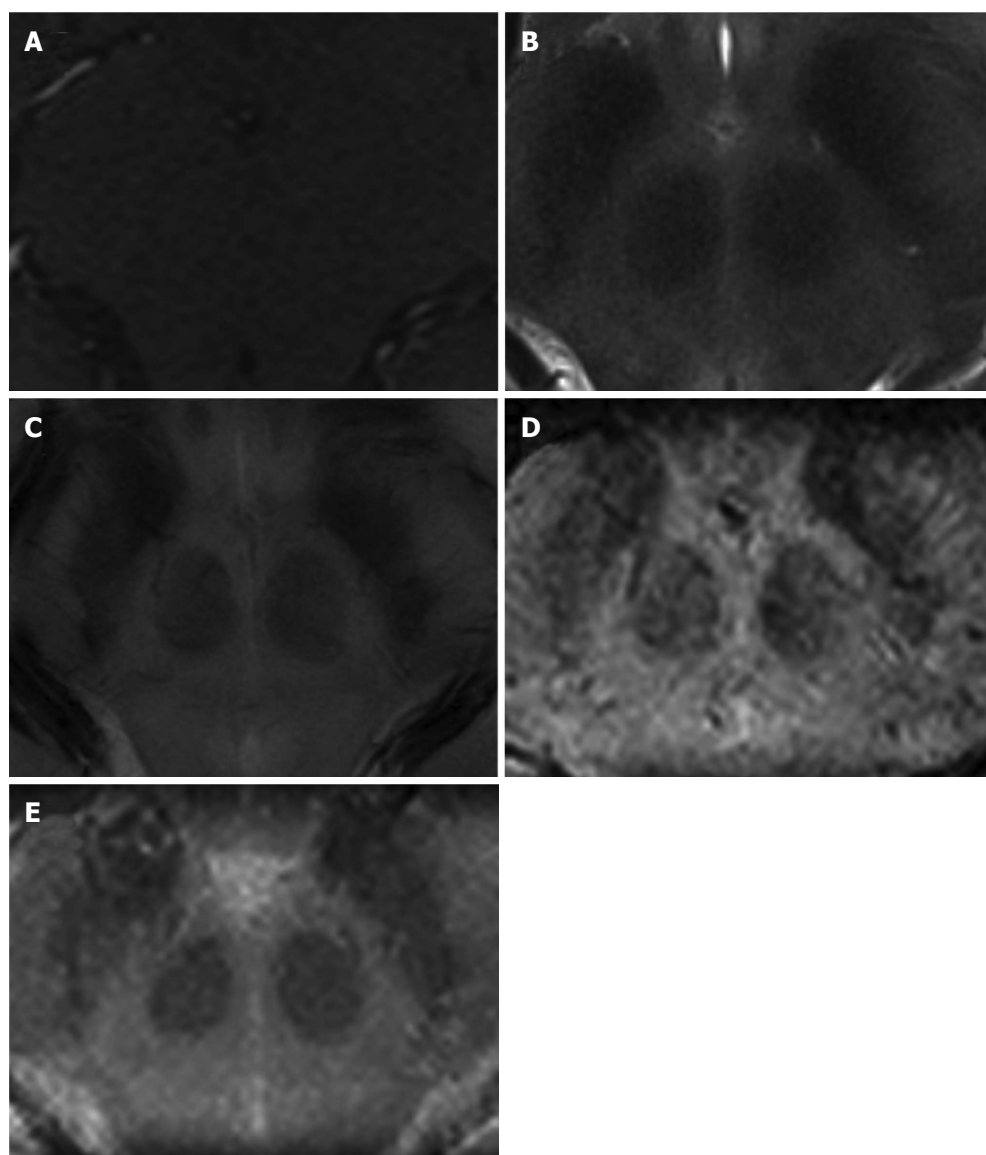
Representative enlarged axial view of the zona incerta. A: T1-weighted gradient-echo transversal; B: T2-turbo spin-echo transversal; C: FLASH2D-T2Star transversal; D: Susceptibility-weighted imaging (SWI) transversal; E: SWI-minimum intensity projections transversal.
